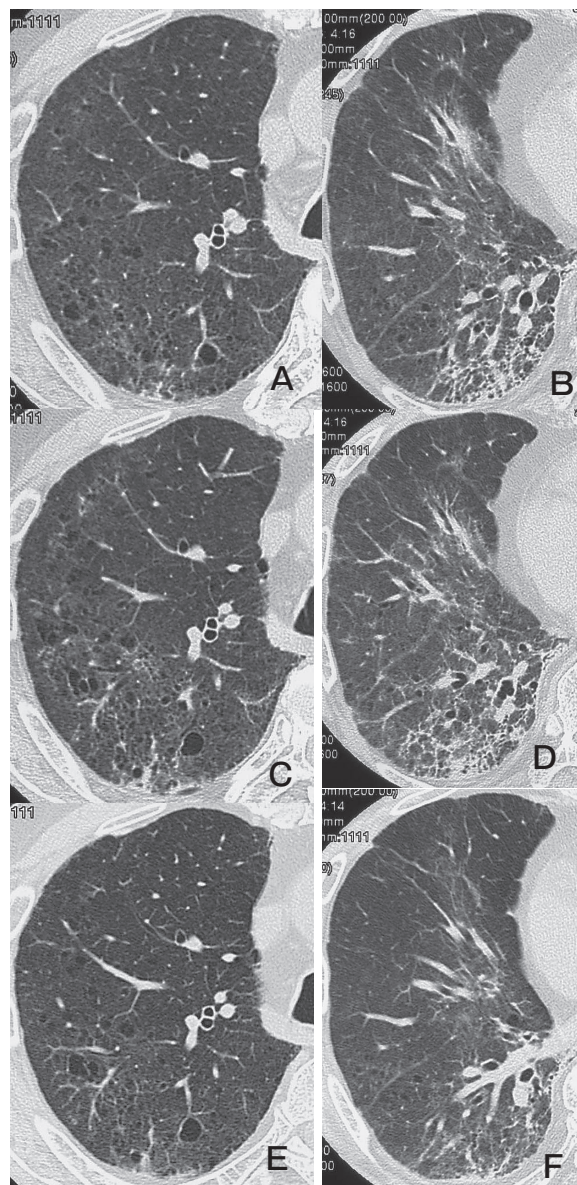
Panels A and B show the HRCT findings in case 9 one day before TMP/SMX introduction, panels C and D show the HRCT findings 5 days after TMP/SMX introduction, and panels E and F show the findings 60 days after introduction. The diffuse infiltration in the periphery of the right upper lobe in panel A and the reticular opacity in the right lower lobe in panel B represent the underlying interstitial pneumonia. This patient received TMP/SMX for 3 days and then the medication was discontinued because of nausea. Irregular infiltration in the middle and the outer zone of right S2 has emerged in panel C, while the underlying reticular opacity in the right lower lobe remains stable in panel D. The previously emerged infiltration in the right upper lobe has disappeared in panel E, and the reticular shadow in the right lower lobe is improved in panel F.
